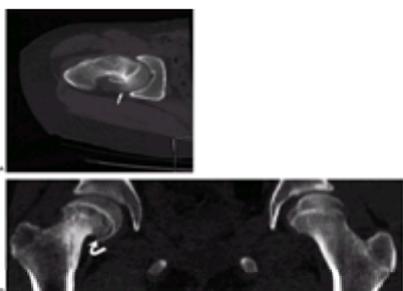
CT evaluation of a slipped capital femoral epiphysis. A 13-year-old girl with several months of right hip pain, which has exacerbated recently. The data set was obtained with 3-mm collimated slices, and reconstructed at 1-mm intervals. A: Axial oblique reconstruction, to display the entire length of the femoral neck, shows that there is a gentle posterior curve of the femoral neck indicating chronic slippage. In addition, the physis is wide and irregular, indicating a superimposed, more acute component. The femoral head (*arrow*) is very displaced posteriorly. B: Coronal reconstruction shows the physeal widening of the right hip (*curved arrow*). By comparison to the degree of posterior slippage, the degree of inferior displacement is relatively minor.
